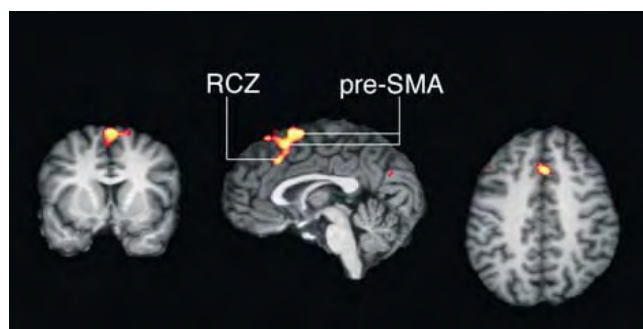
Cortical activations of the contrast of incompatible erroneous trials vs. incompatible correct trials on coronal ($y = 8$), sagittal ($x = 1$) and axial ($z = 38$) slices of a 3D structural MRI; RCZ, rostral cingulate zone; SMA, supplementary motor area.
